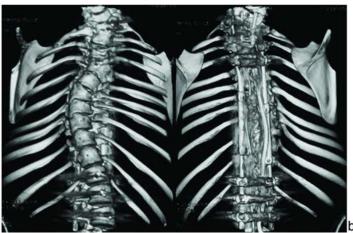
Radiographs (a) and CT (b) of the thoracolumbar spine of the patient, 11 years old, after the operation. S-shaped combined kyphoscoliotic C6–Th2 curve with apex at the level of C7 hemivertebra (relatively): scoliotic component -6° (Cobb), local kyphosis at Th3–6–10 -12° . The thoracic scoliotic curve Th3-Th11 with the apex at the level of Th5 hemivertebra (relatively) -20°
